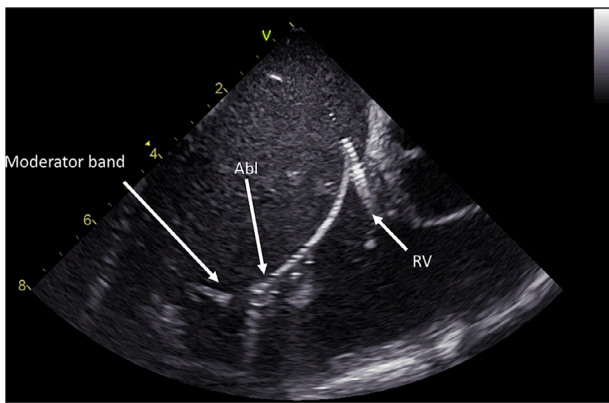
Intracardiac echocardiography image from the right atrium (“home view”). The ablation catheter (Abl), with distal (d) and proximal (p) electrode pairs, is placed at the junction of the moderator band with the septomarginal trabeculations. Also shown is the right ventricular catheter (RV) at the basal septum.
